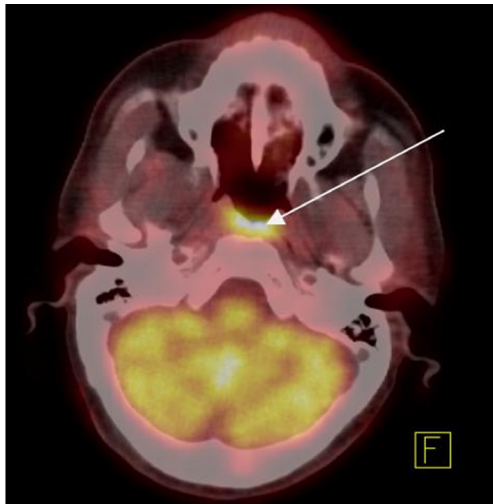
FDG-PET scan showing significantly increased FDG uptake in the posterior pharyngeal wall.
